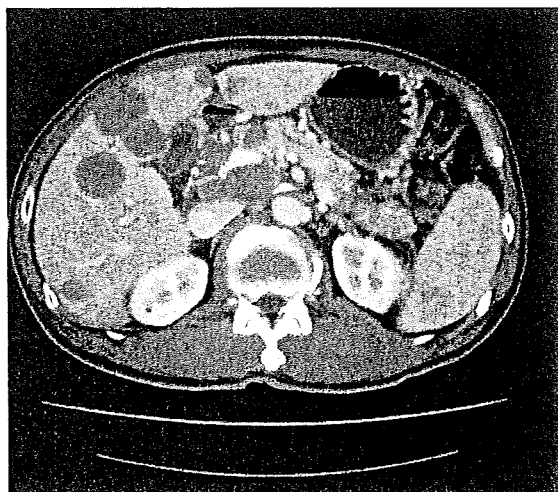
Abdominal computed tomography of Case 2 before treatment. Multiple liver tumors were noted at diagnosis.
